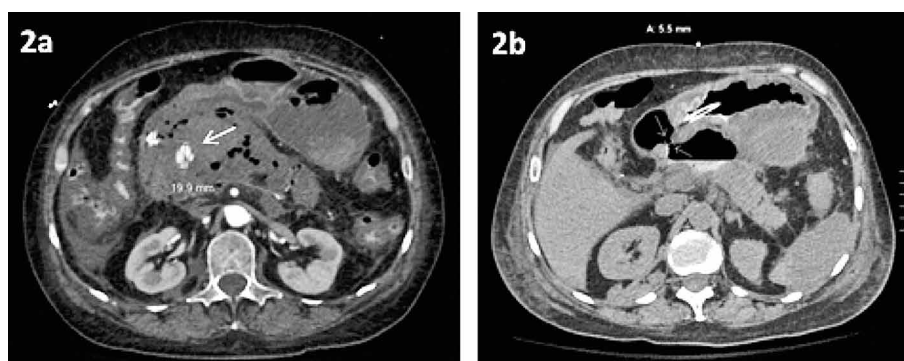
(a) A 1.99cm pseudoaneurysm (arrow) seen within the peri-pancreatic walled-off necrosis (WON) on initial CT scan; (b) Open communication (arrows) between the duodenal bulb and one of the pancreatic collections on repeat CT scan four days later. Decompression of the WON contents is demonstrated.
